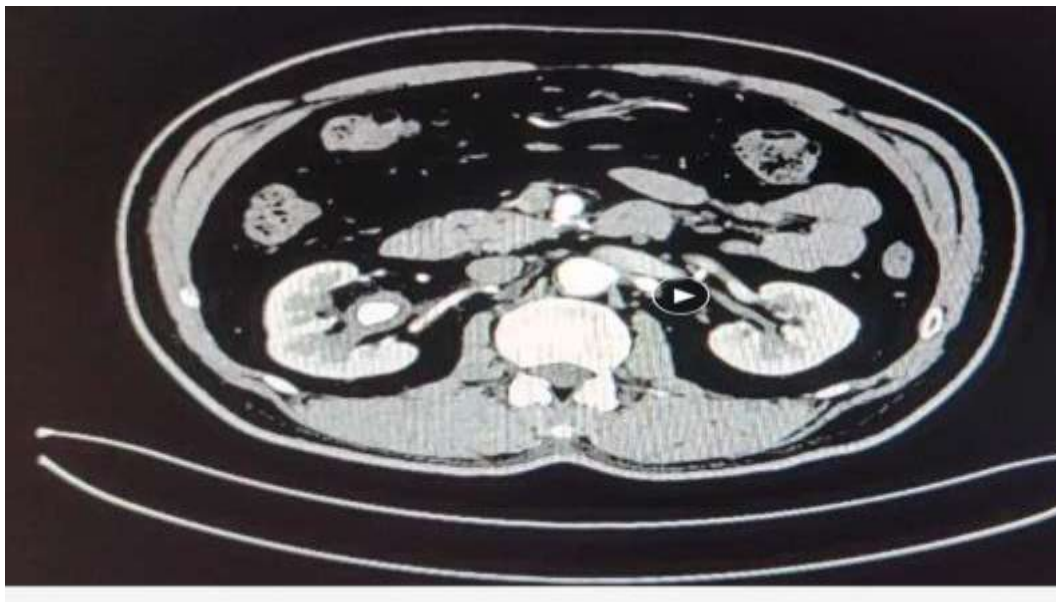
Abdominal CT Showing multiple right renal calculi
